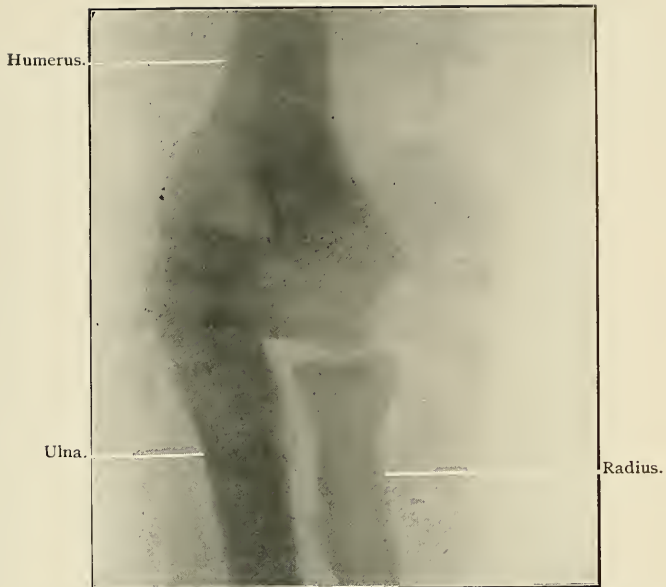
X-ray. Anteroposterior view of the extended elbow of a boy sixteen years old. When eleven years old, fractured the internal condyle. Five years after the fracture, flexion is normal, extension is almost normal (see X-ray plate), pronation and supination are normal. Carrying angle, about normal. Treatment at a right angle. A movable internal condyle can be felt.
